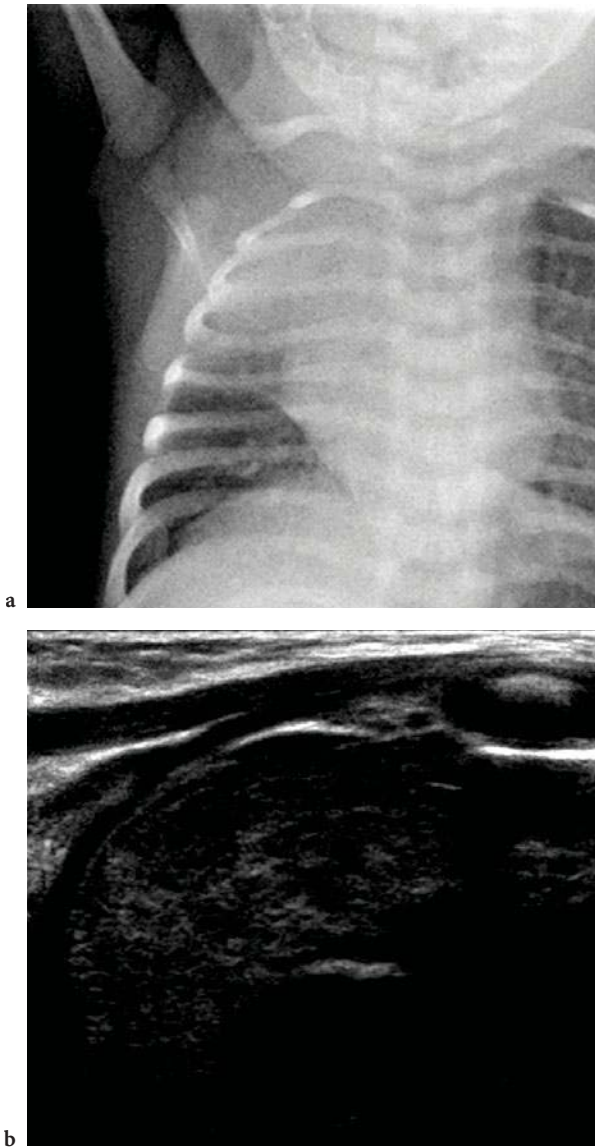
a This neonate had persistent “consolidation” of the right upper lobe that did not respond to treatment. b An ultrasound confirmed the “consolidation” to be a normal thymus
